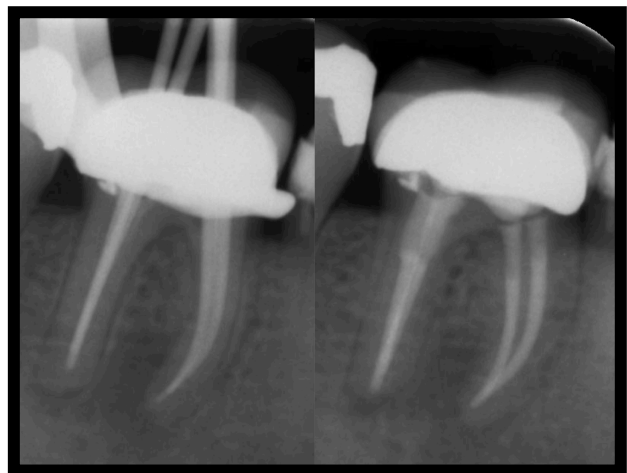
Treatment radiographs. Pooling of bonding resin visible to the right
